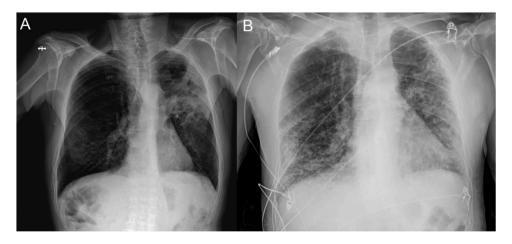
Chest radiograph before start of treatment (A) and at admission because of COVID-19 (B).
